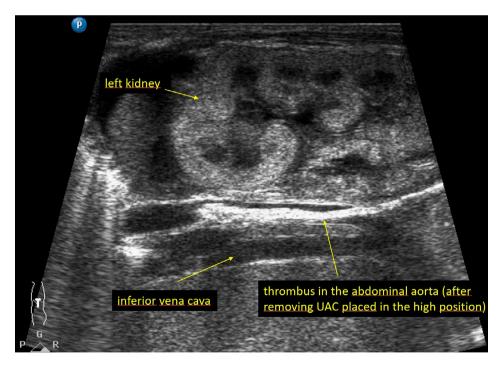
Ultrasound image after removal of a UAC in the high position due to thrombosis. The thrombus extends to the superior pole of the kidney; the inferior pole of the kidney is outside the frame
